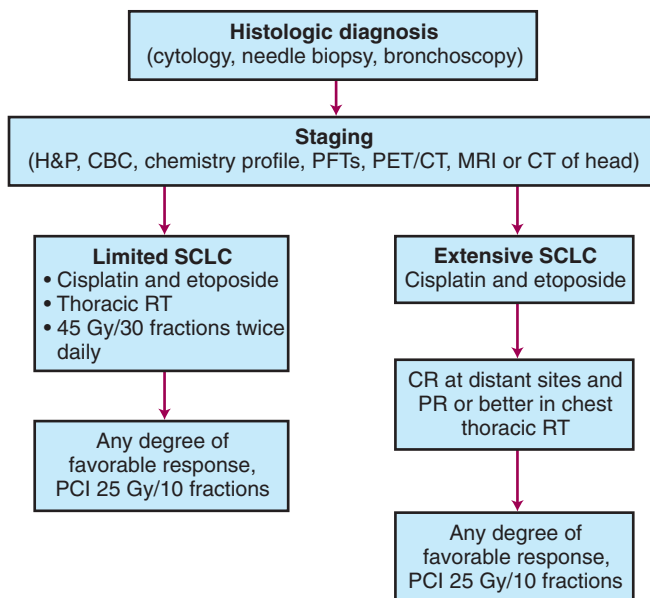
Treatment algorithm for small cell lung cancer. CBC, Complete blood counts; CR, complete response; CT, computed tomography; MRI, magnetic resonance imaging; PCI, prophylactic cranial irradiation; PET, positron emission tomography; PFT, pulmonary function test; PR, partial response; RT, radiotherapy; SCLC, small cell lung cancer.
